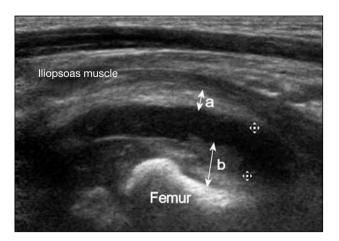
Ultrasound image of a patient with septic arthritis showing the total thickness of anterior and posterior layers of the anterior hip joint capsule (distance a+b) exceeding that of joint effusion (cursors).
